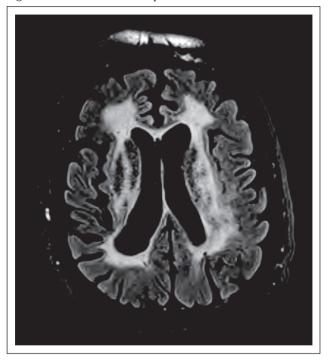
Periventricular caps and bands on axial FLAIR MRI.
